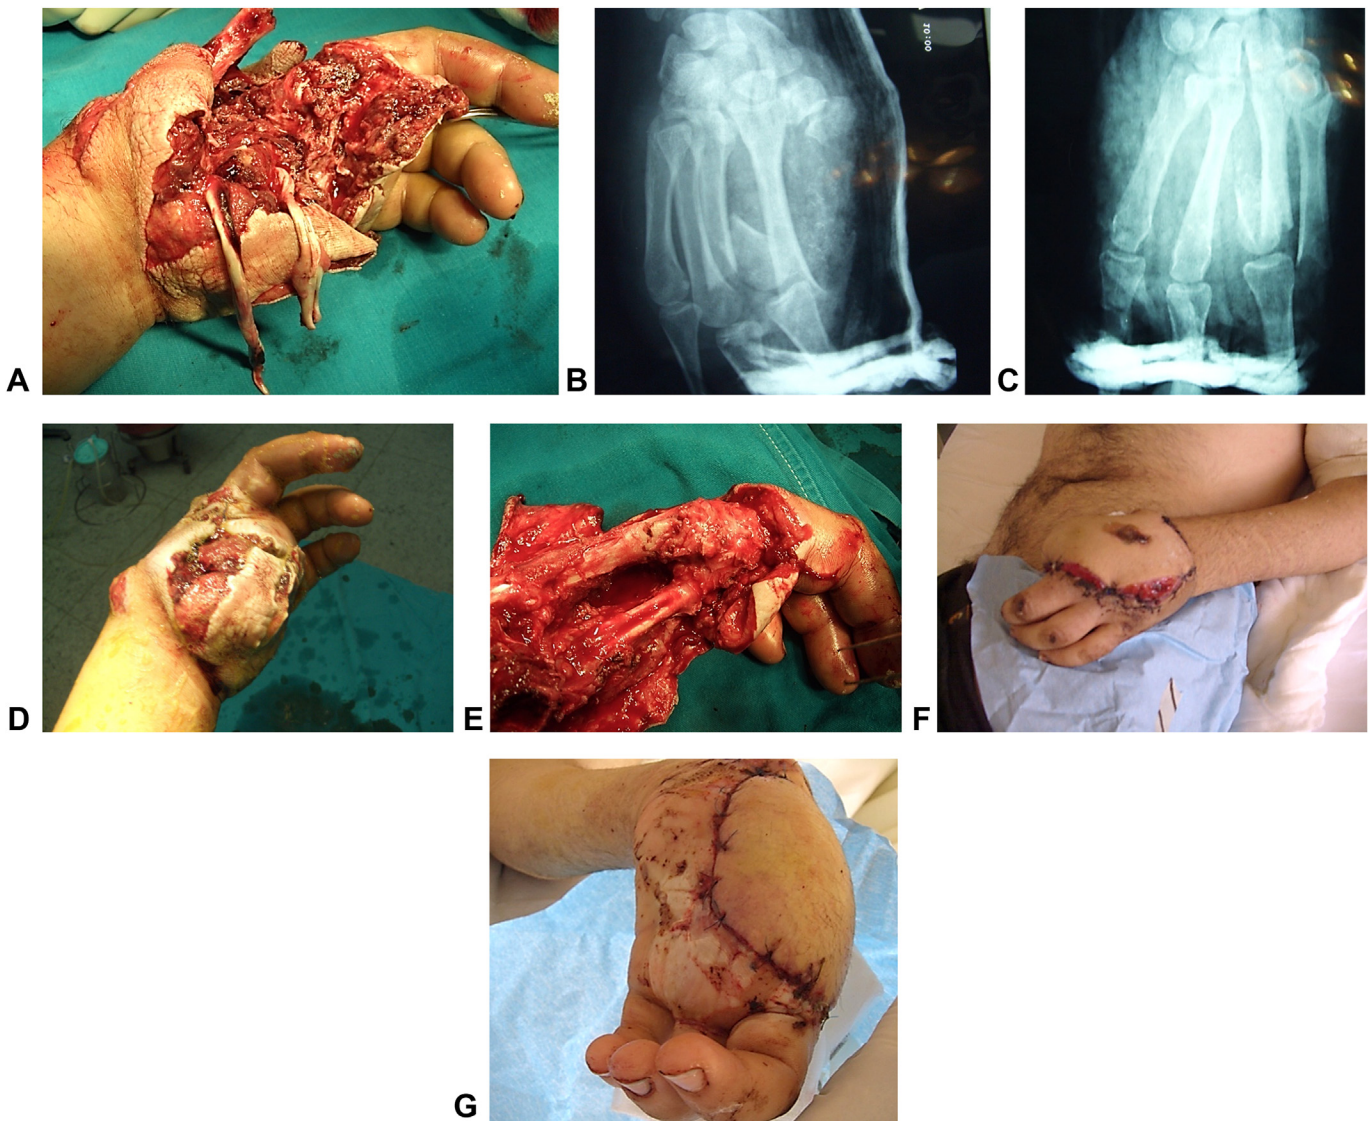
Seventeen years male-blast injury of the left hand with thumb and index finger amputation; A preoperative aspect (emergencies); B, C X-ray aspects; D aspect before second surgery (flap); E after debridement; F the defect covered with a groin flap; and G poor final result.
